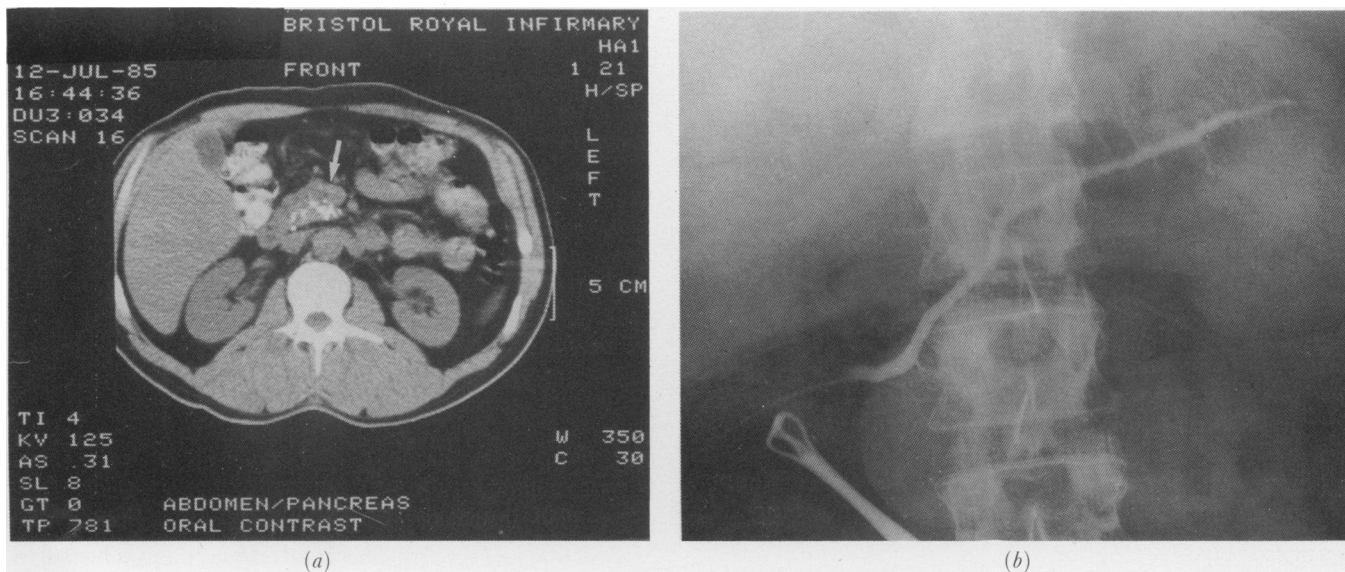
Radiography in a 51-year-old man with recurrent pancreatitis for 2 years. The CT scan (a) shows calcification in the head of pancreas (arrowed). At operation the duct of Wirsung could not be found. Cannulation of the accessory papilla was difficult because of stenosis, but the duct of Santorini was radiologically normal (b).
